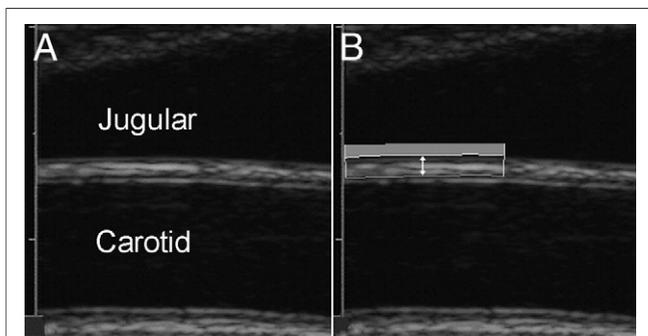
High-Resolution Ultrasound Image of the Carotid Extra-Media Thickness
